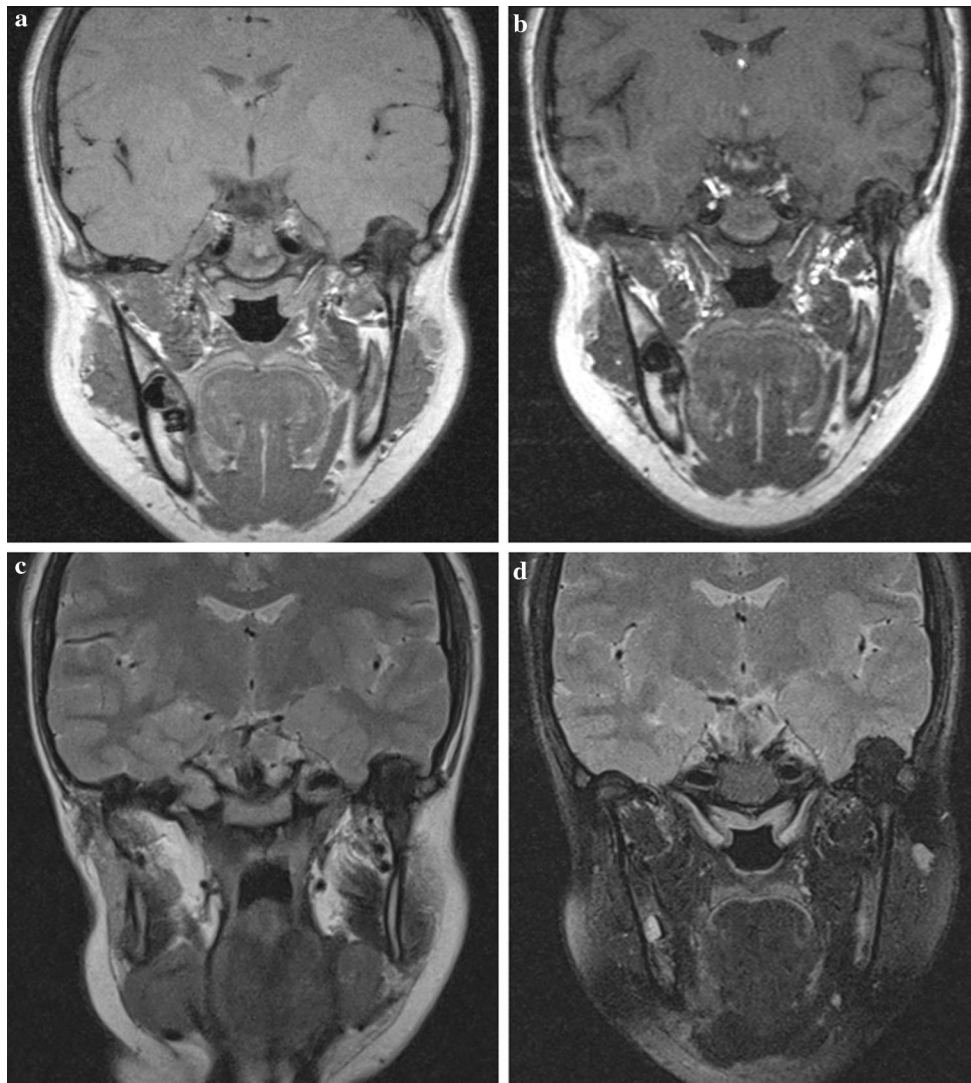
MRI images. a Proton density image. b T1-weighted image. c T2-weighted image. d STIR sequence image. The images show displacement of the temporal lobe tissue of the brain caused by a
